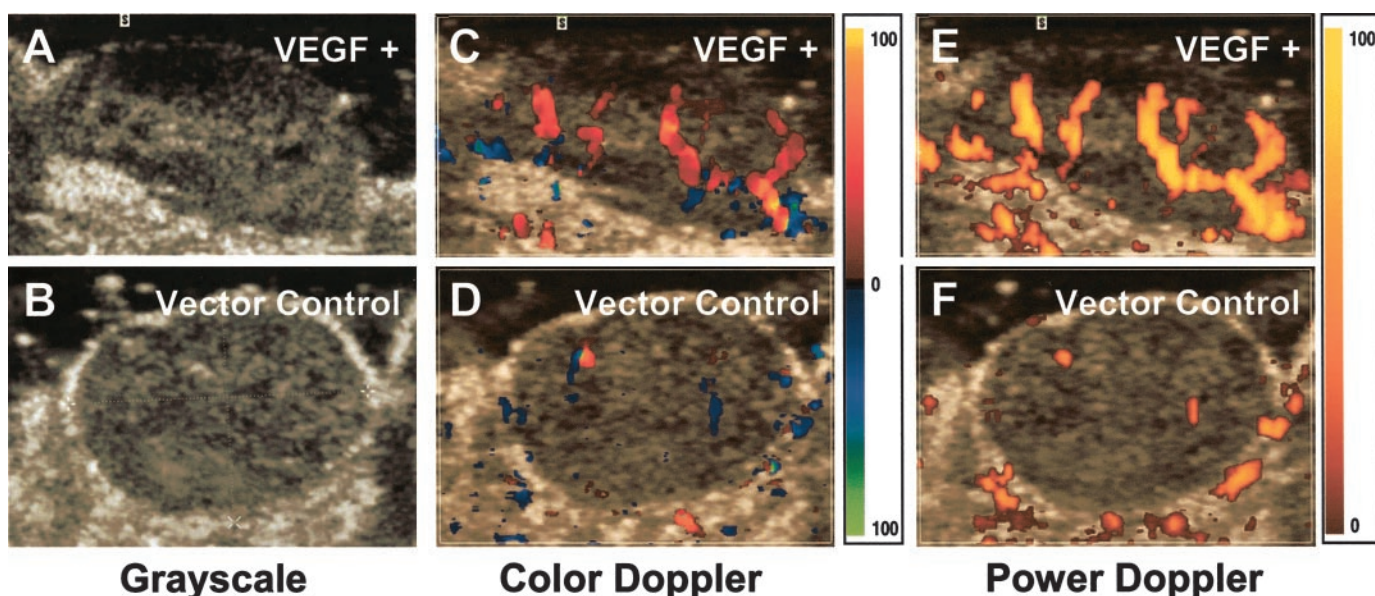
Color and power Doppler images of VEGF+ (top panels) and Vec (bottom panels) tumors. The *left column* represents the gray-scale images. The *middle column* shows the color Doppler images (BF), and the *right column* shows power Doppler images (BV). There is a marked difference in the number of blood vessels and intensity of color/unit area of tumor in VEGF+ tumors when compared with the Vec tumors.
